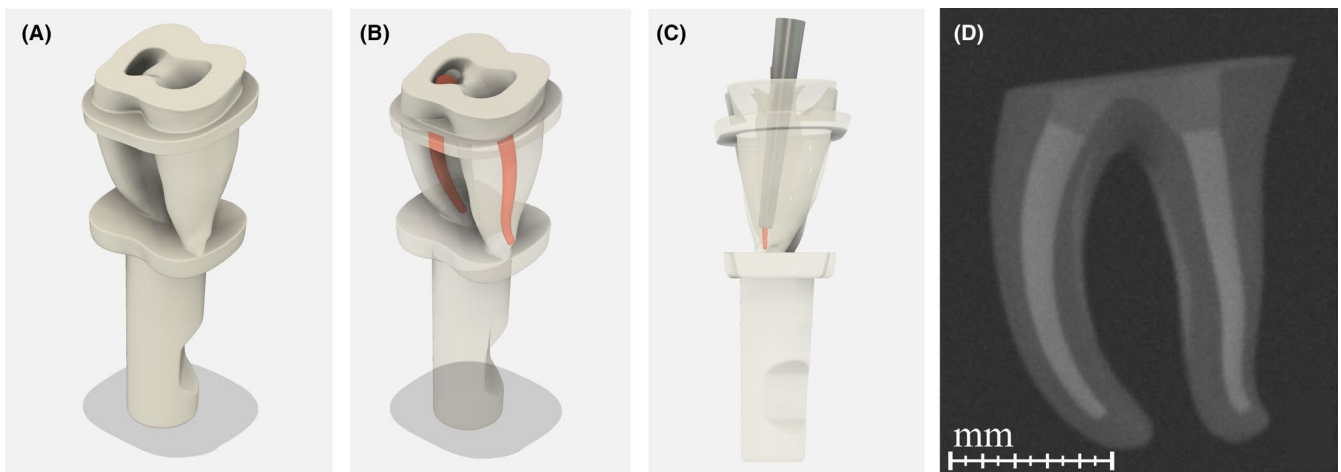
The tooth adapted for the dental study model (A); construction of an ideal root canal preparation and filling (B); construction of an ideal fitting dentin post (C); and the designed radiograph of the tooth with visible root canal filling (D) [Colour figure can be viewed at wileyonlinelibrary.com]
